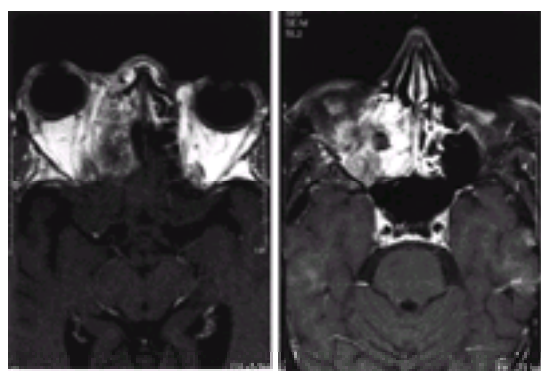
Nasopharyngeal carcinoma. (a) Axial T₁-weighted gadolinium-enhanced MRI of a tumor arising the right ethmoid, deforming the medial aspect of the orbit and growing up against the gyri of the basal frontal lobe. (b) A parallel axial T₁-weighted gadolinium-enhanced image of the same tumor at a more inferior level, showing invasion of the orbit.
